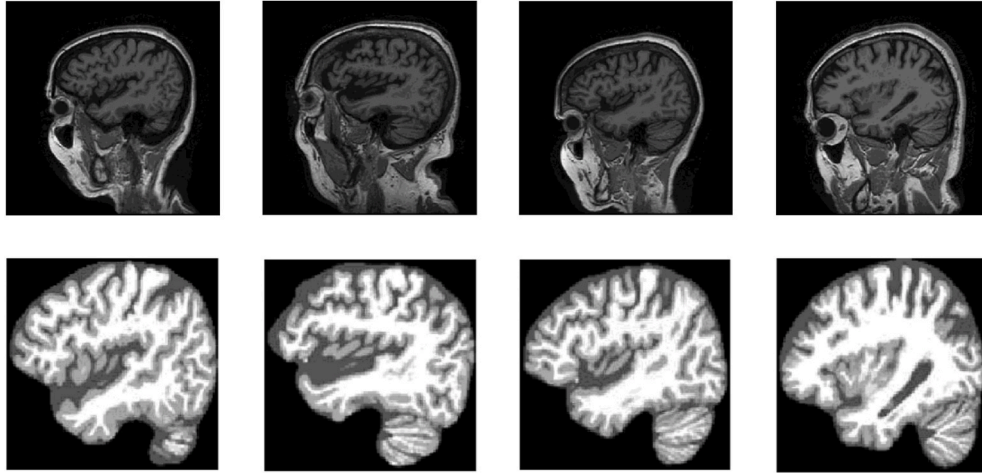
Examples of MRI slices before (top) and after (bottom) processing. Left to Right: CN, sMCI, AD, and pMCI, respectively.
